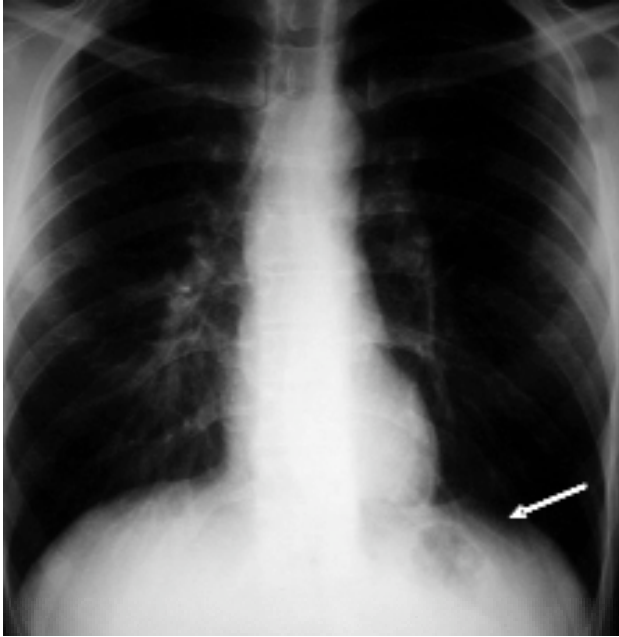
Chest X-ray indicating loss of sequence of the left diaphragmatic border (arrow).
